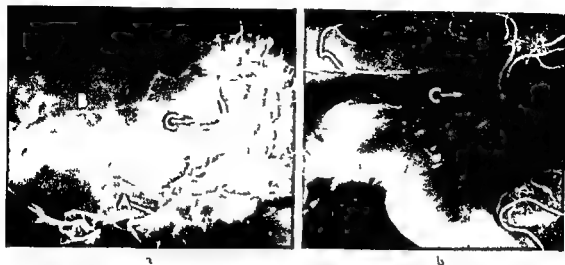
a) Lateral view of postmortem roentgenograms. The posterior cerebral artery (A) is injected and joins the anterior cerebral artery (B) via the callosal branch (C). b) Radiograph of sagittal brain section (mid line cut). The callosal branch (C) connects the posterior cerebral artery with the anterior cerebral artery.
